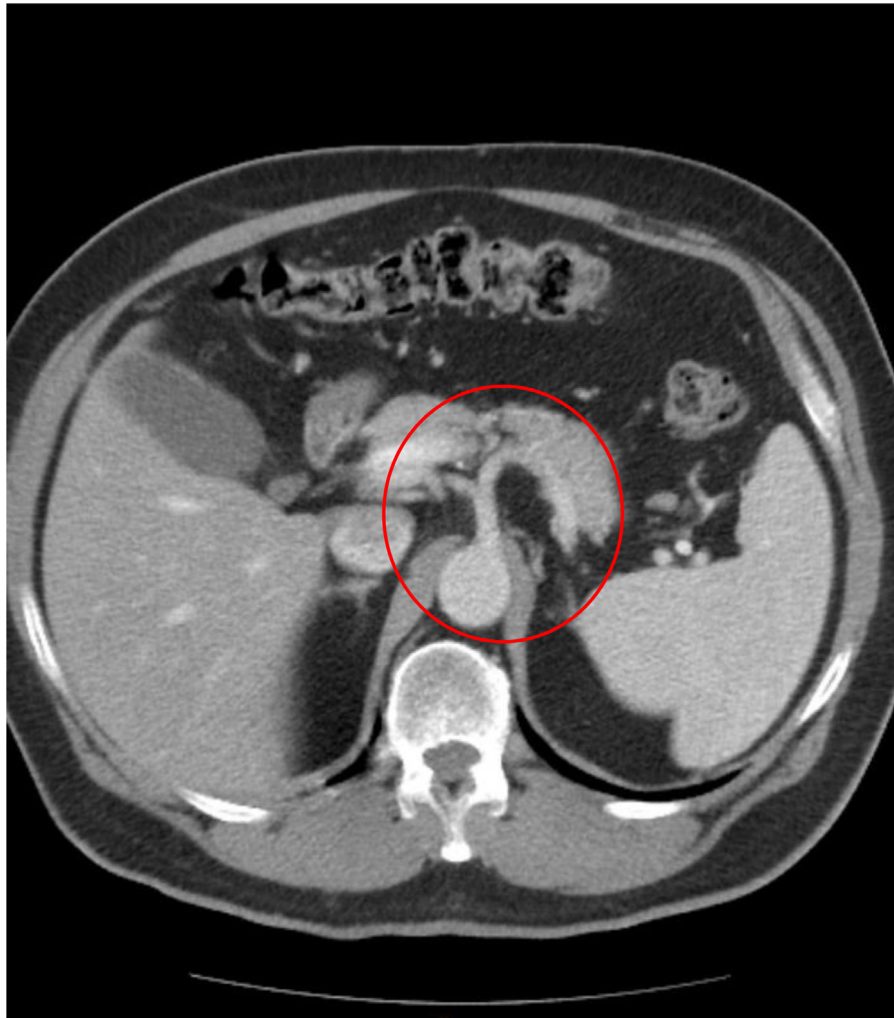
CT Chest/Abdomen/Pelvis with contrast performed 3 months prior to arterial dissection demonstrating patent celiac, splenic, and common hepatic arteries with no evidence of dissection.
